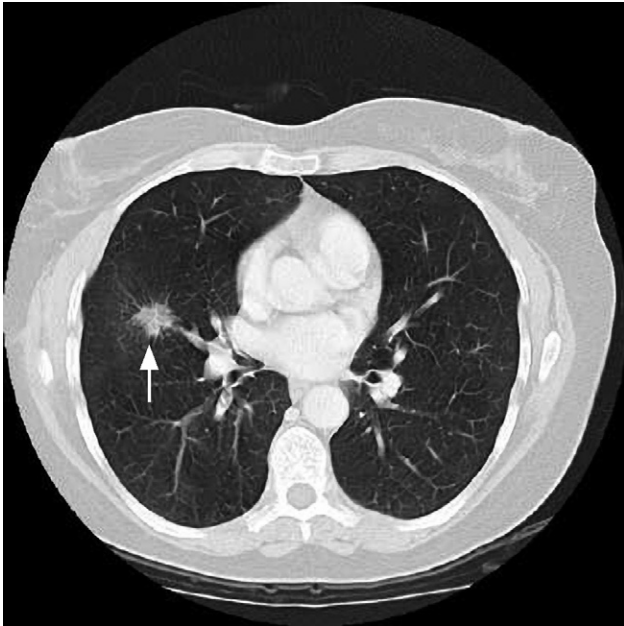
Typical appearance and small size of a carcinoma of the bronchus discovered incidentally at CT.
